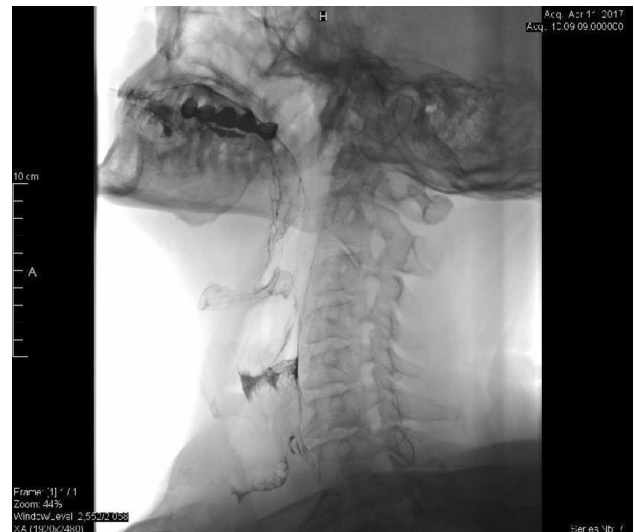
The fistula in the lower third of the neck; Barium X-ray Swallow
